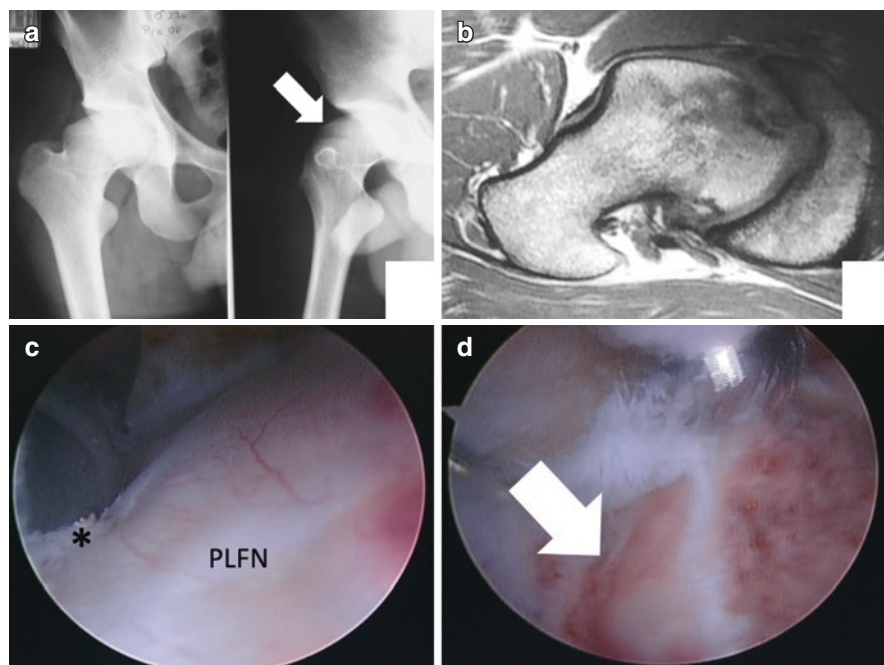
Severe CAM deformity in a right hip. (a) The white arrow demonstrates a posterior extension of the CAM deformity. (b) Corresponding MR image showing the size of the deformity. (c) Endoscopic image of the posterior synovial fold (*) and blood vessels going into the posterior lateral femoral neck (PLFN). (d) CAM remodeling with the right visualization of the vascularity to prevent injury (white arrow)
